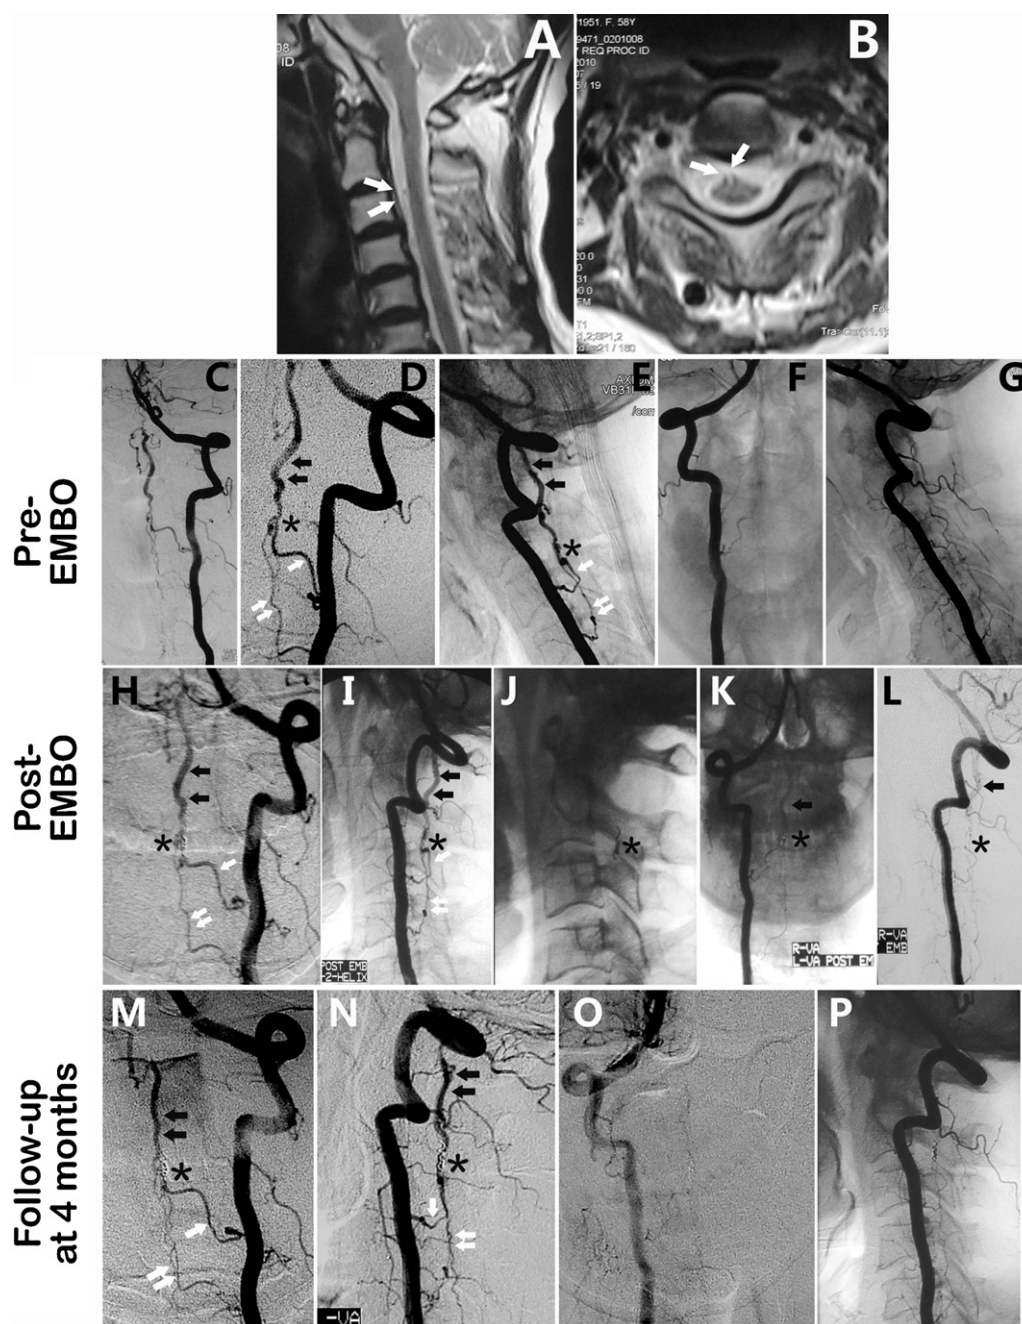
Cervical spine MRI (A, sagittal T2; B, axial T2): abnormal flow void signals in the ventral surface of C2 (indicated by white arrows); (C–G) angiogram before the endovascular embolization; left VA (C–E) and right VA (F and G) angiogram showed the fistula point (noted by asterisk, D–E). Two anterior radicular arteries arose from left VA, and served as the feeding arteries. They were indicated by single (the larger one) and double (the smaller one) white arrows respectively (D and E). They contributed to the fistula at level of C2–C3 vertebral bodies. The arterialized vein coursed up anterior to the cervical spinal cord (black arrow, D and E). Minor contributing flow arose from right radicular arteries (F and G). (H–L) Angiogram after the embolization; a coil was deployed (asterisk, J). The feeding blood flow from left VA was decreased (H–J) and the fistula was not completely closed (K and L). (M–P) Angiogram 4 months after the embolization: left (M and N) and right VA (O and P) angiogram showed the fistula was not completely obliterated; feeding arteries and draining vein were noted by white and black arrows, respectively; a coil, deployed previously can be identified (asterisk). VA, vertebral artery.
